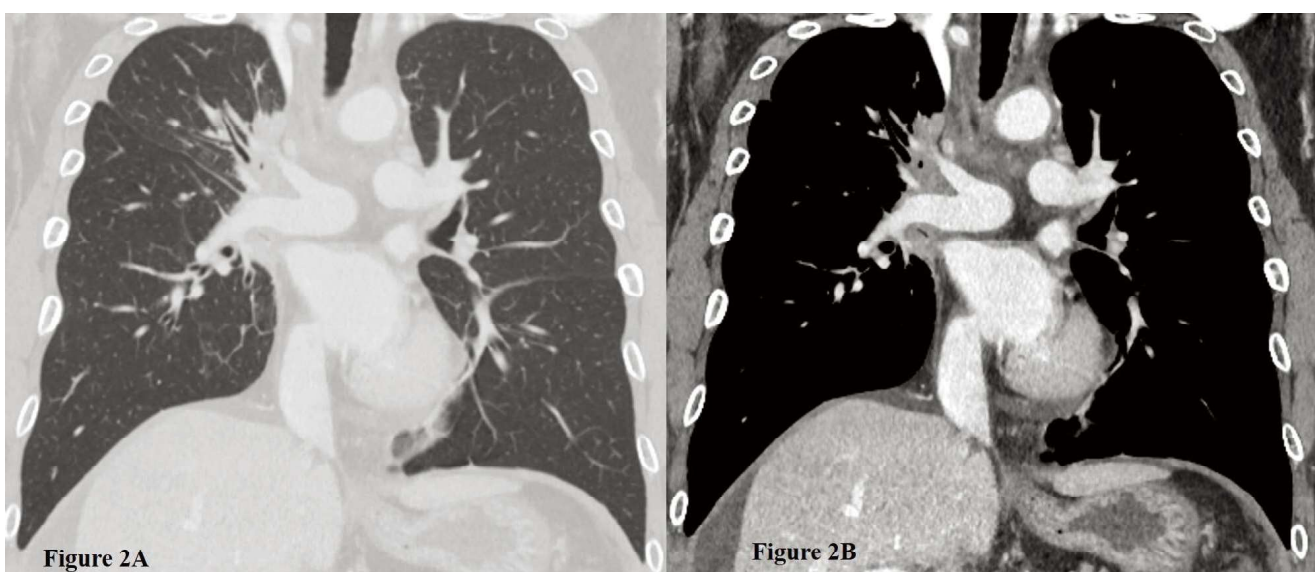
Coronal view of the lung (A) and mediastinal (B) window of the patient's chest CT at the onset of chylous effusion. No specific sign of lung tumor progression was noted in the lung window, although some ascites was observed in the mediastinal window.
